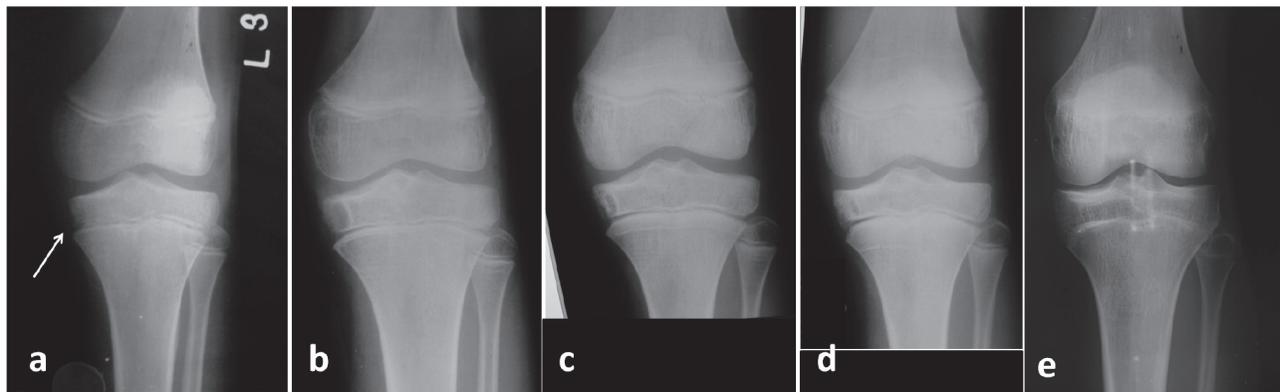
Same patient as above (a) Plain radiographs showing radiolucent cyst in medial tibial condyle with ill defined margins (white arrow) (b) Margins of lesion became well defined after 6 months of chemotherapy (c) Progressive lesion obliteration seen 1 year after completion of chemotherapy (d) Follow up 3 years (e) Last follow up 5 years. Complete healing.
